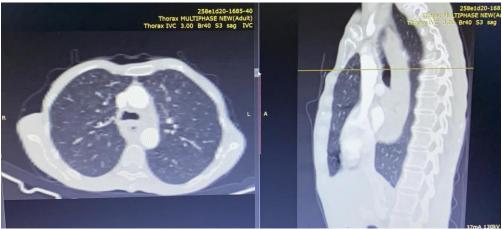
CT scan preoperatively
